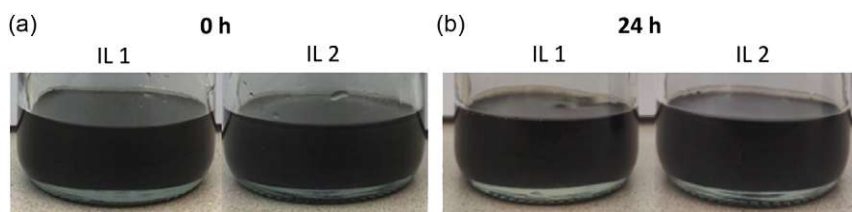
MXene dispersion in the ionic liquids IL1 and IL2 a) directly after stirring and ultrasonication and b) after 24 h.
